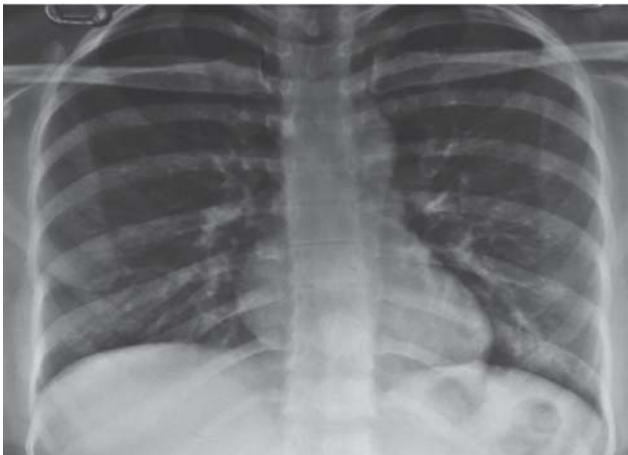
Chest radiograph (postero-anterior view) done during follow-up at 10 days showing complete resolution of pleural effusion.
